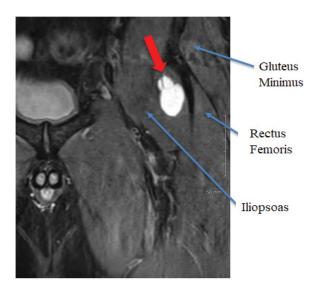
MRI Left Hip (Coronal View): This demonstrates the left hip paralabral cyst (red arrow) with extension into the left iliopsoas muscle belly.
